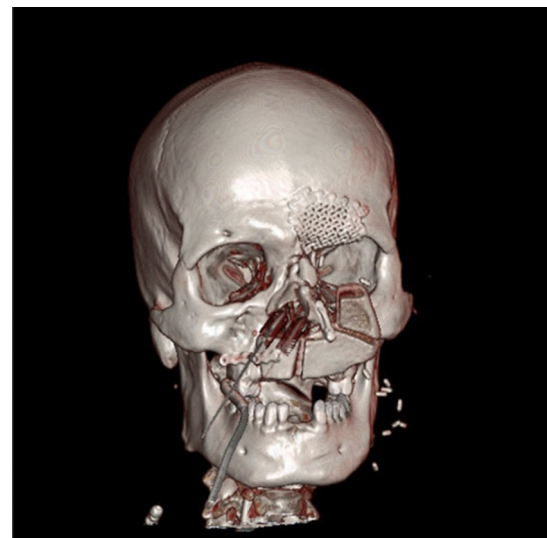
The postoperative three-dimensional CT scan after 1 month of surgery, demonstrating the adapted free osteotomized iliac bone flap.
